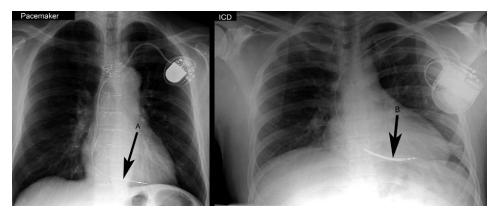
PA radiographs of a patient with a pacemaker (left) and ICD (right) are shown. Arrow A shows the right ventricular lead of the pacemaker which does not have a radiodense coil. Arrow B shows the right ventricular lead of the ICD.
